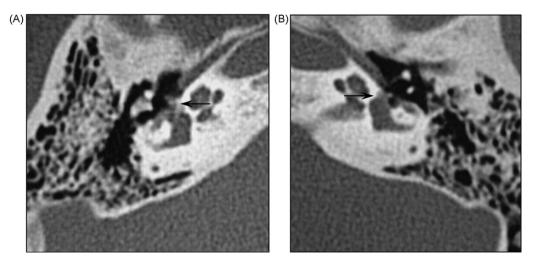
(A and B) Axial computed tomographic scan of a 13-year-old girl (Patient #2) with bilateral otosclerosis. Black arrows indicate, on both sides, poorly calcified foci in the cochlear capsule just anterior to the oval window.
